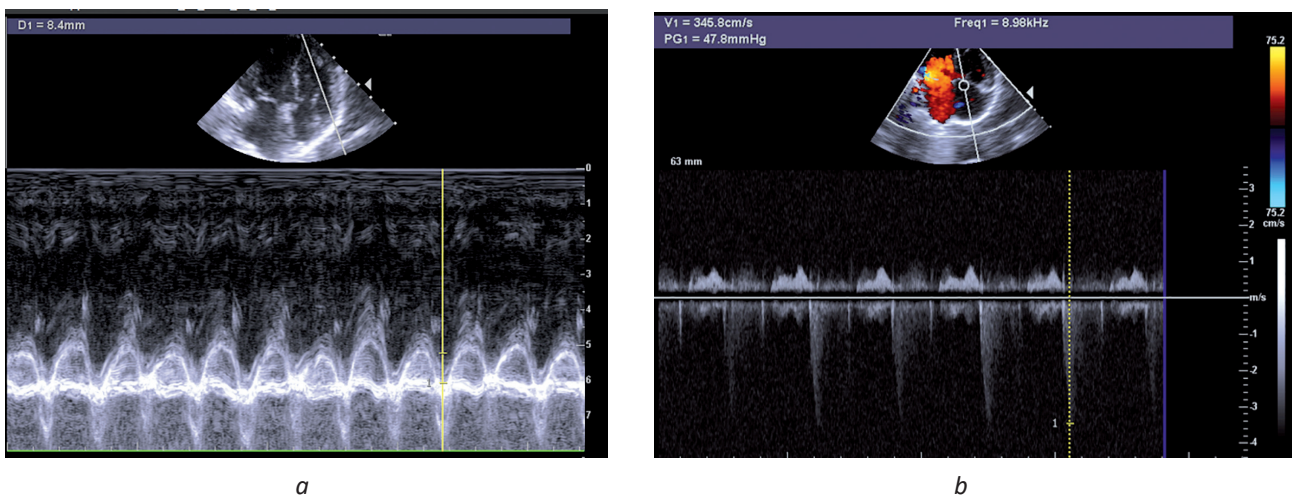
Echocardiography measurement of TAPSE (a) and SPAP (b) from apical four-chamber view
